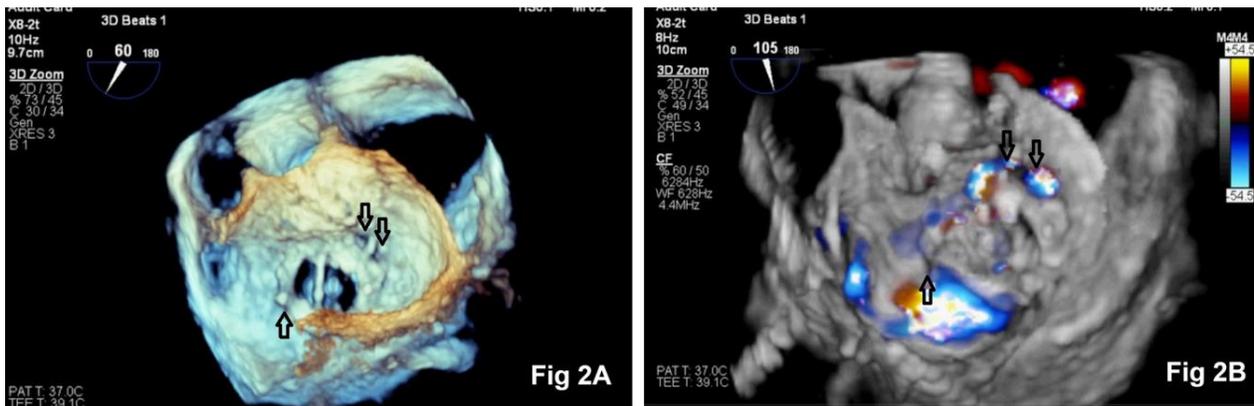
Three-dimensional (3D) en-face view of the mitral valve demonstrating two paravalvular leaks at the 2 o'clock position and one at the 7 o'clock position (Figure 2A). 3D en-face view with color Doppler (Figure 2B)
